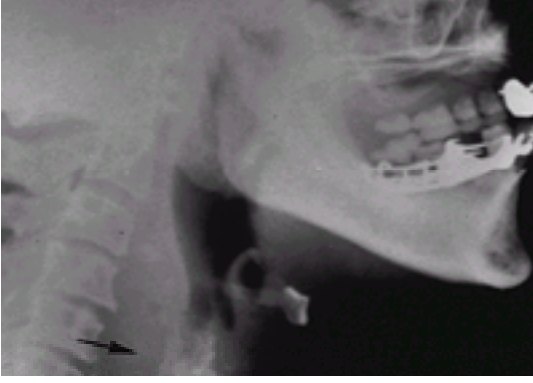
Lateral neck radiograph demonstrating retropharyngeal abscess (*arrow*).
